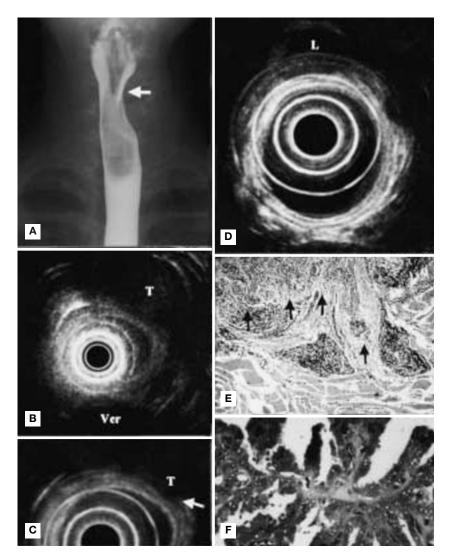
A) Esophagography revealing irregular compression (arrow). B) Endoscopic ultrasonography (EUS, 7.5 MHz) showing a hypo-echoic tumor of the thyroid left lobe (T) and vertebrae (Ver). C, EUS (20 MHz) showing discontinuity of the fourth layer (arrow) by thyroid cancer infiltration (T). D) EUS (20 MHz) showing a metastatic paratracheal lymph node (L). E) Muscularis propria of the esophagus invaded by papillary carcinoma demonstrated in a predominantly solid pattern (arrow). F) Branching configuration of the papillae in the well-differentiated part of the papillary carcinoma.
